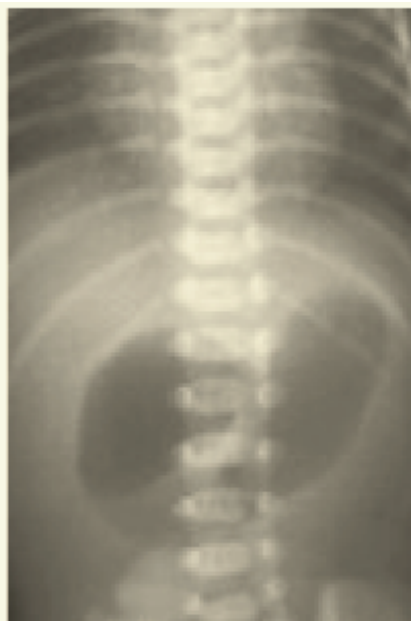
Abdominal X-ray shows single gas field bubble, very distended stomach and no gas in distal portions, suggesting pyloric atresia.
